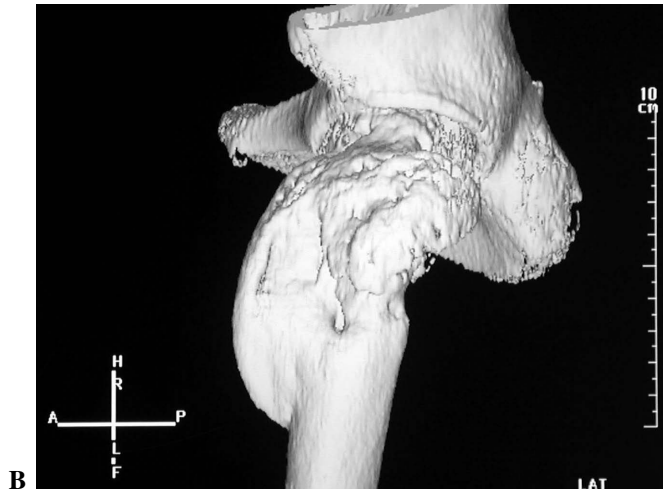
Three dimensional CT visualizing varus and retroversion of the femoral neck. (A: anterior view, B: lateral view, C: posterior view).
